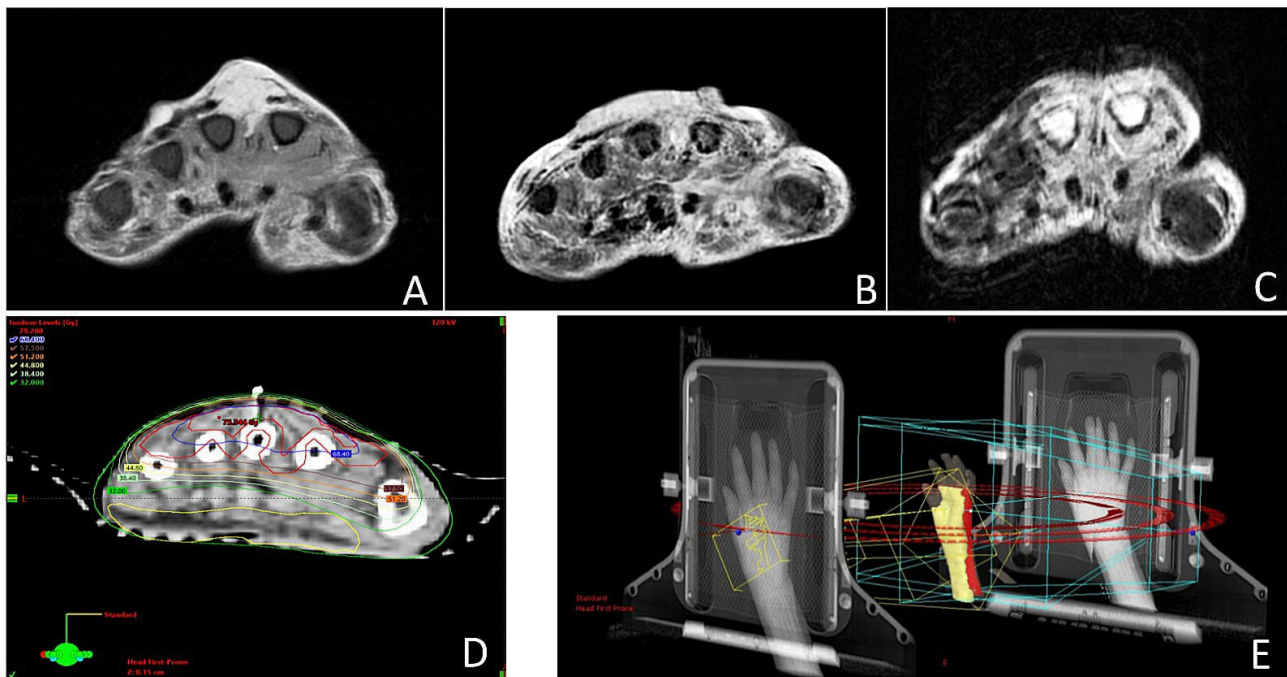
Comprehensive multimodal imaging and dosimetric evaluation. (A,B) Pre- and post-surgical magnetic resonance imaging (MRI). (C) MRI six months after the completion of radiotherapy showed no signs of recurrence. (D) Isodose levels of the treatment plan, with each color representing a different isodose: green corresponds to 32 Gy, light green to 38.40 Gy, light yellow to 44.80 Gy, orange to 51.20 Gy, brown to 57.50 Gy, and blue to 68.40 Gy. The 68.40 Gy isodose, corresponding to 95% of the prescribed dose for the boost, is shown. The gross tumor volume (GTV) is depicted in pink, while the plantar skin is shown in yellow. (E) Digitally reconstructed radiography (DRR), with the plantar skin outlined in yellow and the target surface in red.
